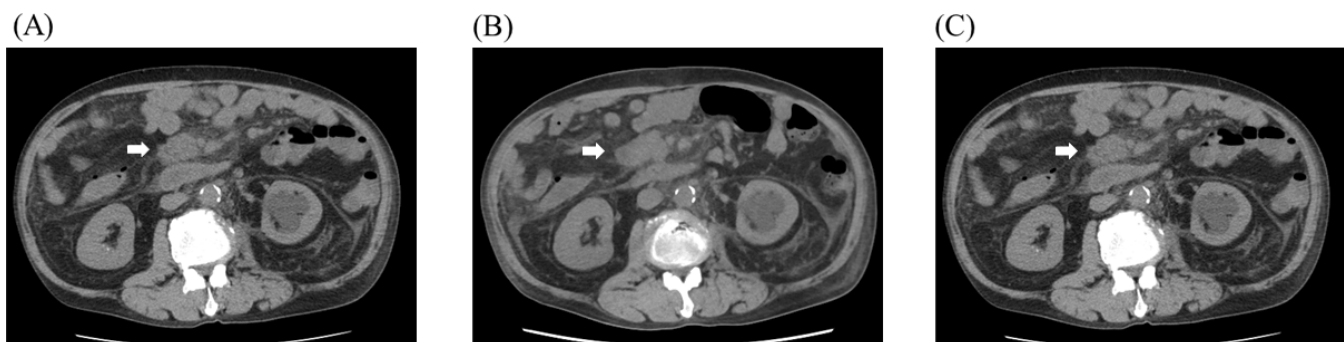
Abdominal CT image showing mesenteric metastasis (arrow; A): note that the representative metastasis is shown, and the other metastases to the mesentery are not shown. The abdominal CT image obtained on day 14 showing an enlargement of the mesenteric metastasis (arrow; B), which shrank on day 36 after the treatment initiation (arrow; C). CT, computed tomography
